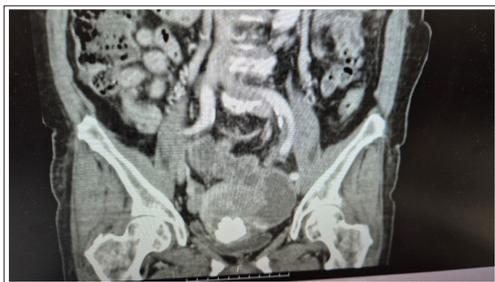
Preoperative CT Finding- Calcified 11cm Irregular
